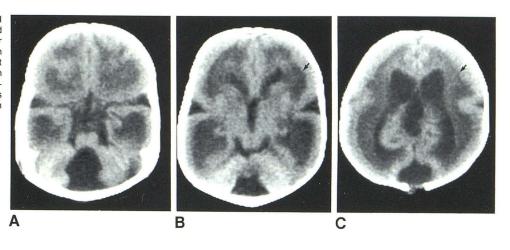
Case 7 (case 3 in [2]). Type II lissencephaly in WWS. A, CT scan at 1 day. B, Higher cut. Severe hydrocephalus but no posterior fossa cyst. Faint smooth subsurface line may be seen in places despite hydrocephalus. Ventricular wall (*white arrows*). Subsurface line (black *arrows*). Dense band of tissue has obliterated anterior interhemispheric fissure; this observation should suggest WWS even if other details are obscured. Dense septum passing obliquely across both cuts most likely represents displaced dural structure surrounded by thick fibroglial rind (it was not specifically described in pathologic report).
